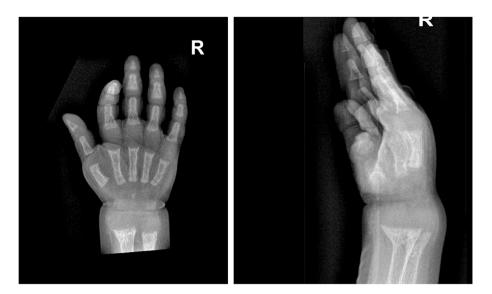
Case 6: antero-posterior (left) and lateral radiographs (right) of the right hand showing marked cupping, fraying, and splaying of ulnar and radius distal metaphysis.
